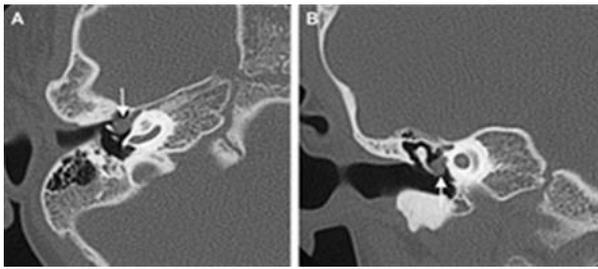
Congenital cholesteatoma. (a) axial section and (b) coronal section CT scan temporal showing rounded soft tissue with a flat edge in the middle ear space
